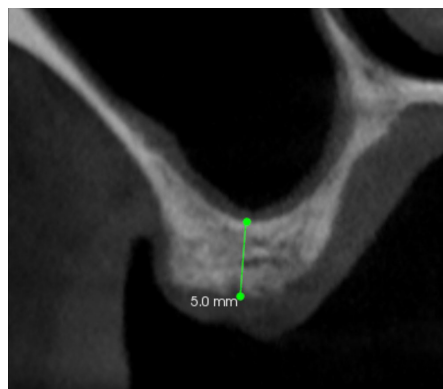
CBCT cross-section UL6 site
